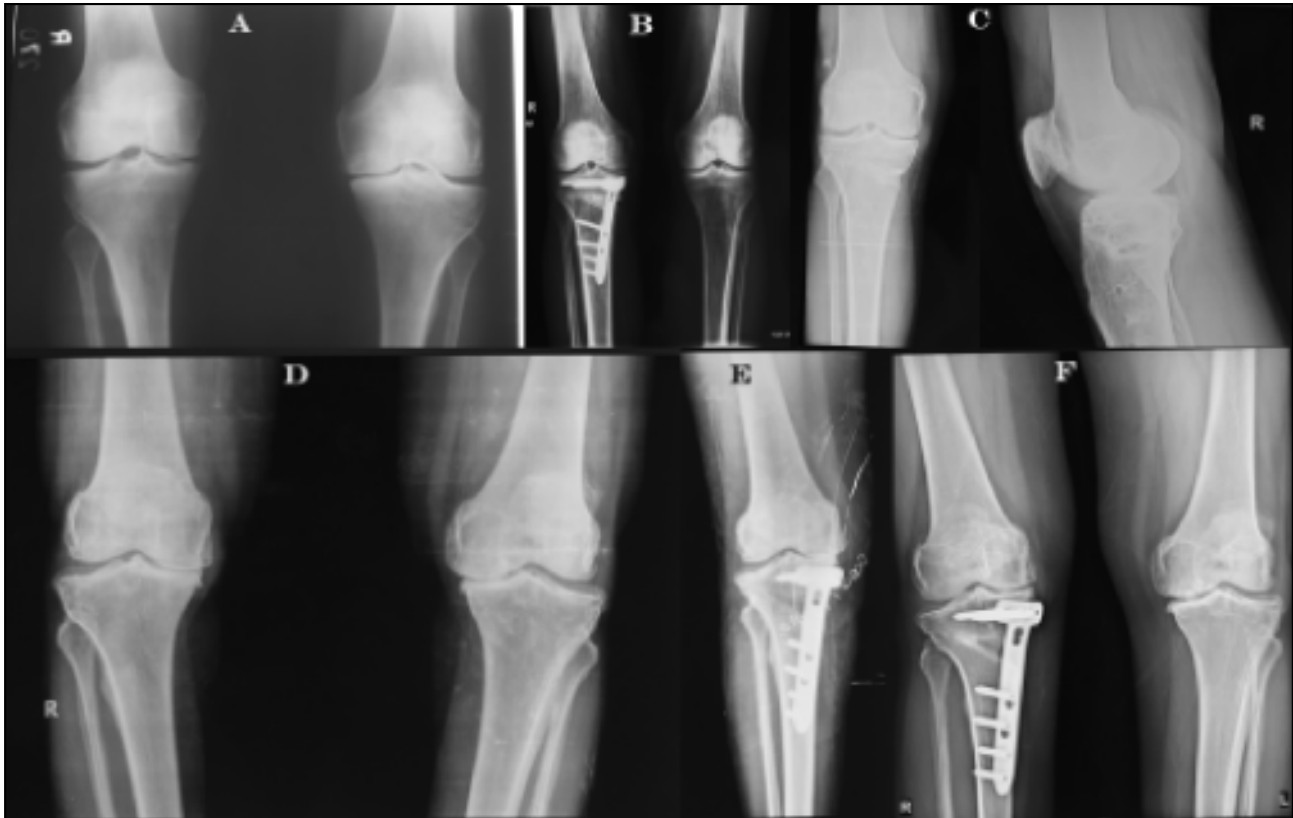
Full weight bearing preoperative X-ray of a 66 year old male;
